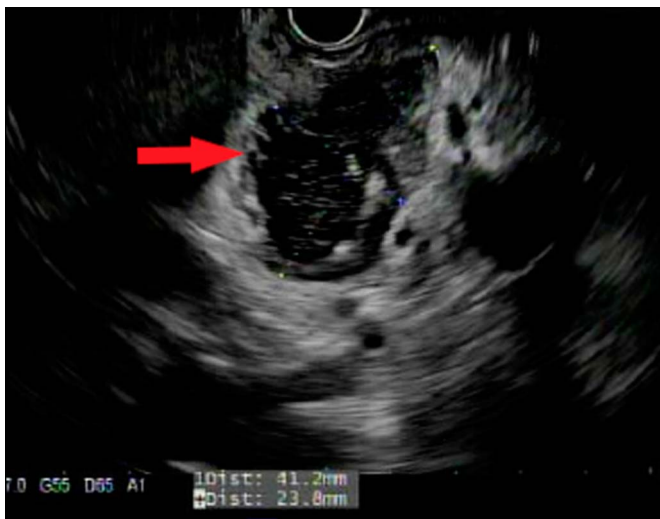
Endoscopic ultrasound image showing a retroperitoneal fluid collection of 4×2.4 cm with heterogeneous thick-walled structure and mobile internal debris at the second portion of the duodenum (red arrow).
